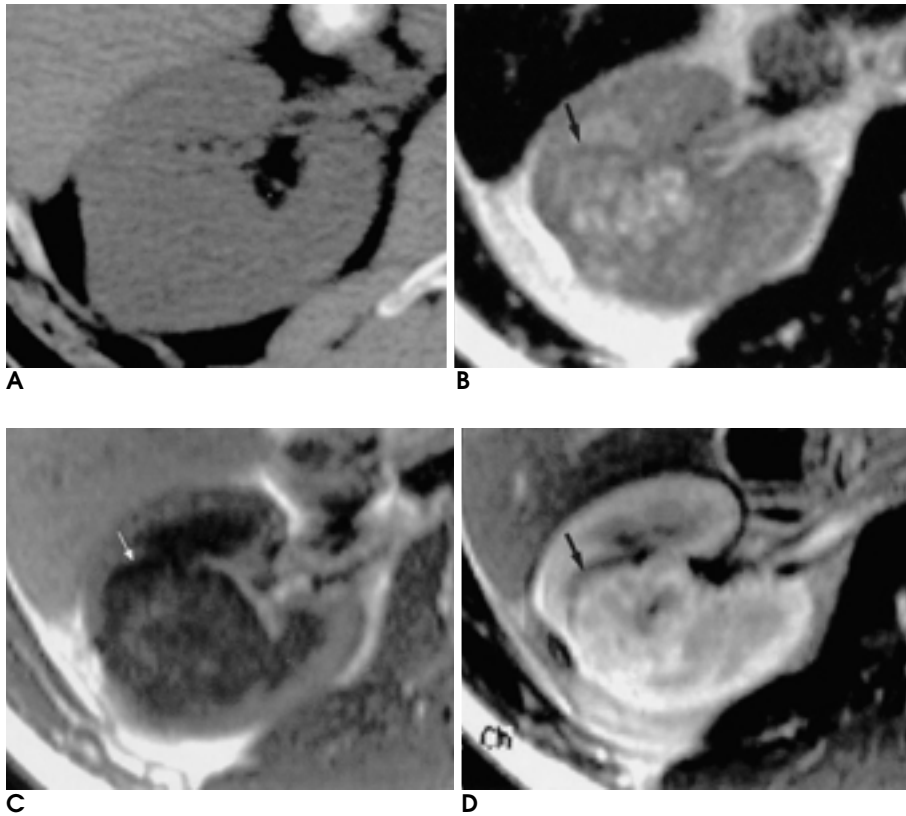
A 48-year-old man with renal cell carcinoma. A mass lesion is not clearly defined on non-enhanced CT scan (A) as it is isodense to renal parenchyme, but MR images well demonstrate a mass lesion. It is a heterogeneous hyperintense mass on T2-weighted image (B) and a medium-signal intensity mass on T1-weighted image (C). Enhanced T1-weighted MR image (D) shows a heterogeneous mass with moderate contrast enhancement. Note the partially visible pseudocapsule (arrows).
